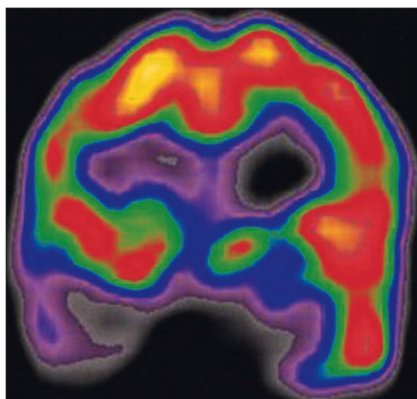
Ictal single photon emission computed tomography shows abnormally increased perfusion areas on subcortical area above the calcified area of right frontal lobe.
